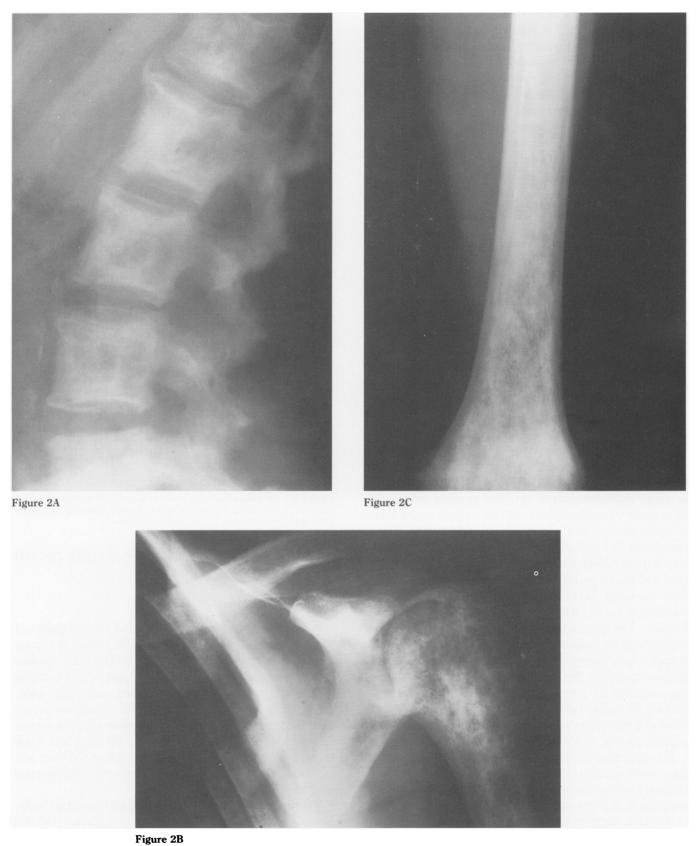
(A) A lateral roentgenograph of the lumbar spine reveals diffuse osteoblastic and osteolytic changes. (B) Roentgenographs of the proximal humerus and scapula, and (C) distal femur exhibit a permeative pattern of patchy sclerosis and osteolysis with no evidence of cortical expansion or destruction.
